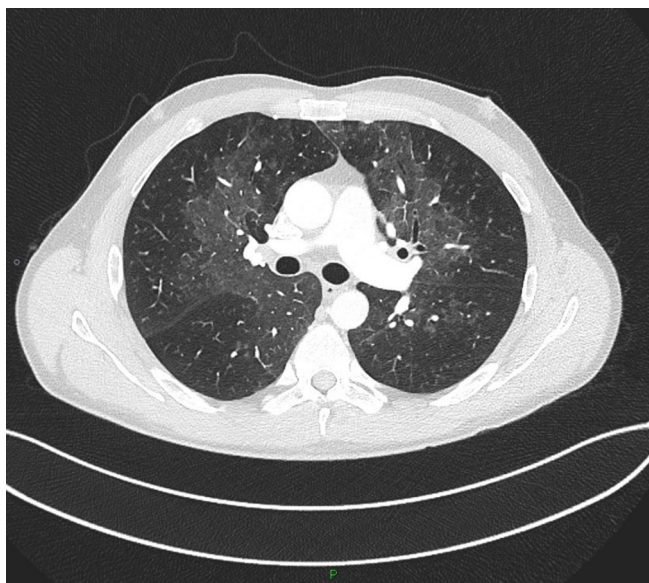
Repeat CT pulmonary angiogram 2 weeks later.
